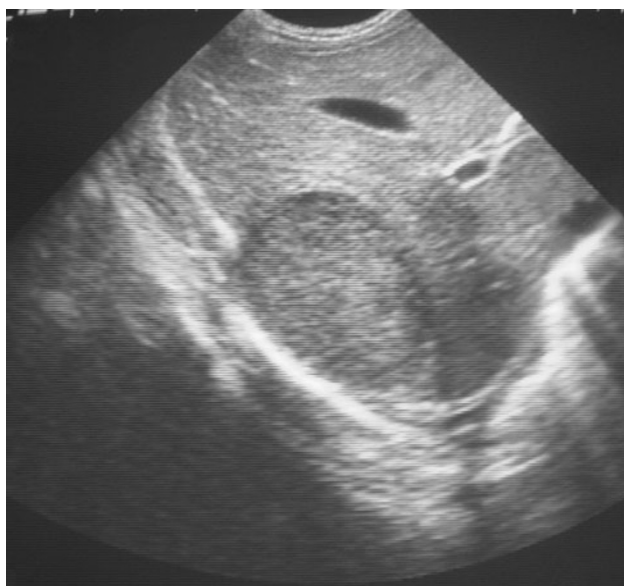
Ultrasound image: liver lesion in the subdiaphragmatic area
